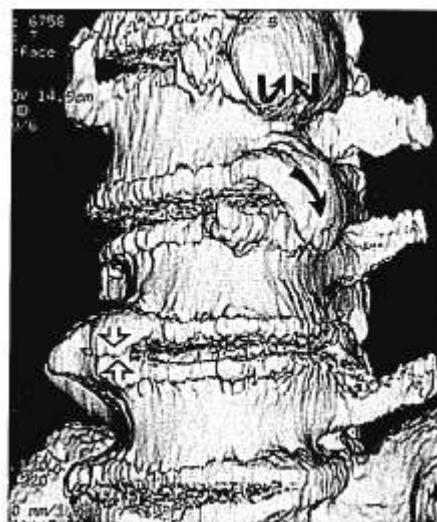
Ventral three-dimensional computed tomography 3D CT (3D CT) study demonstrates marked osteophytic lipping at the L2–L3 (retrolisthesis), L3–L4, and L4–L5 levels (case 3). The ventral 3D CT scan of this 69-year-old man with disabling neurogenic claudication demonstrated increased olisthy at L2–L3, and severe osteophytic lipping at L2–L3 (double curved arrows), L3–L4 (curved arrow), and L4–L5 (double open arrows).
